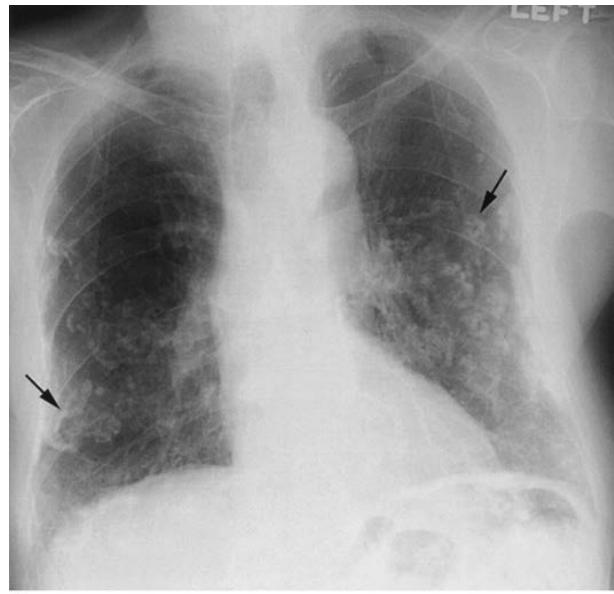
Asbestosis. A. Frontal chest radiograph shows bilateral calcified pleural plaques consistent with asbestos-related pleural disease. Poorly defined linear and reticular abnormalities are seen in the lower lobes bilaterally. B. Axial high-resolution computed tomography of the thorax obtained through the lung bases shows bilateral, subpleural reticulation (black arrows), representing fibrotic lung disease due to asbestosis. Subpleural lines are also present (arrowheads), characteristic of, though not specific for, asbestosis. Calcified pleural plaques representing asbestos-related pleural disease (white arrows) are also evident.
